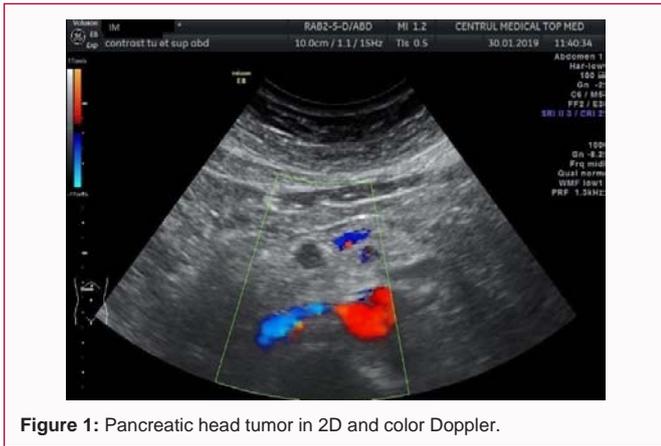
Pancreatic head tumor in 2D and color Doppler.
